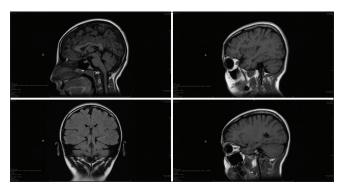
Brain MRI showing global atrophic changes
